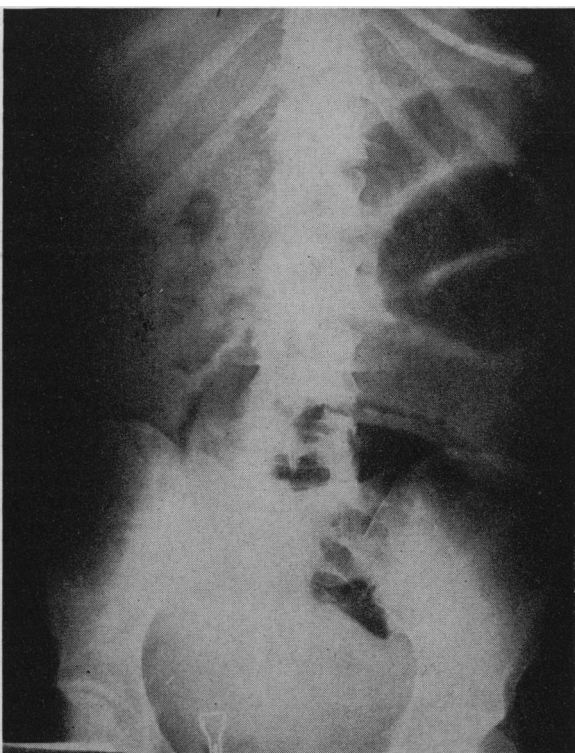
Plain film of abdomen reveals distended loop of intestine with a "herringbone" pattern typical for small intestine. The patient, aged 30, had a cesarean section 12 days previously and had abdominal pain with nausea and vomiting for two days prior to admission. Decompression was effective; the tube was removed in 24 hours and feedings begun. Obstruction recurred and operation was performed. An adhesion at the suture line was found obstructing a loop of mid-ileum. Decompression longer than 24 hours might have resulted in relief lasting at least for several days, thus allowing restoration of the physical condition to normal. Operation could then have been performed in an interval phase when the operative risk was optimum.
